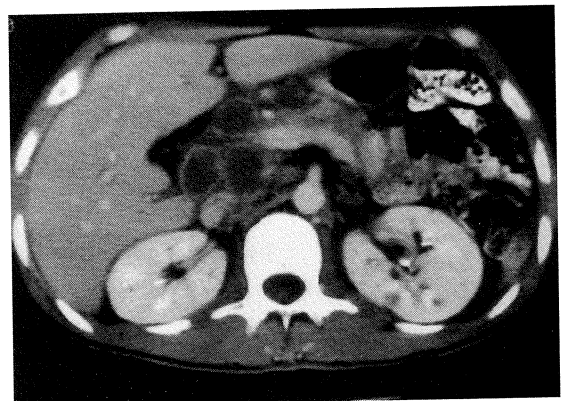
CT scan: Lobulated masses with rim enhancement.
